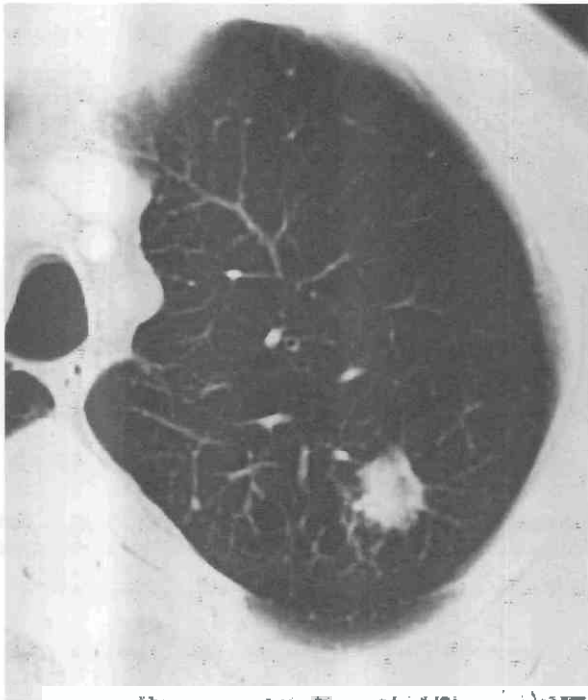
Malignant fibrous histiocytoma manifesting as a solitary pulmonary nodule. CT shows a left upper lobe nodule with irregular margins.
